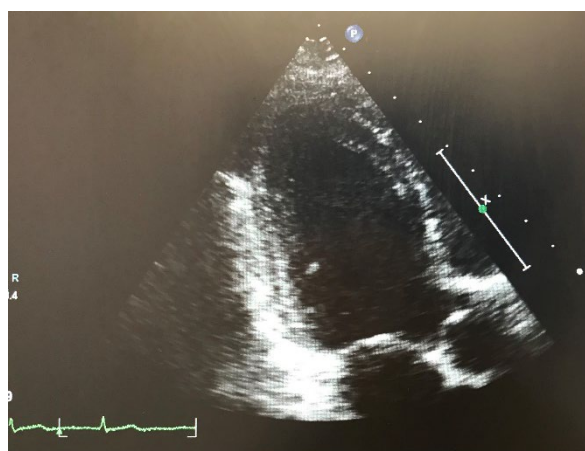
Apical three chamber view
